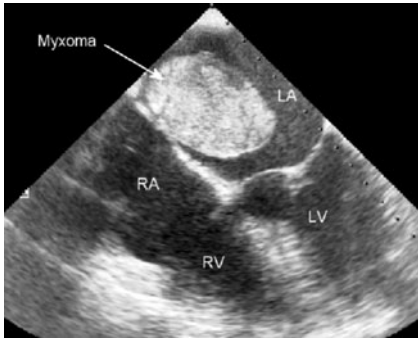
Transoesophageal echocardiography demonstrating a large myxoma attached to the septum between the right atrium (RA) and left atrium (LA)
